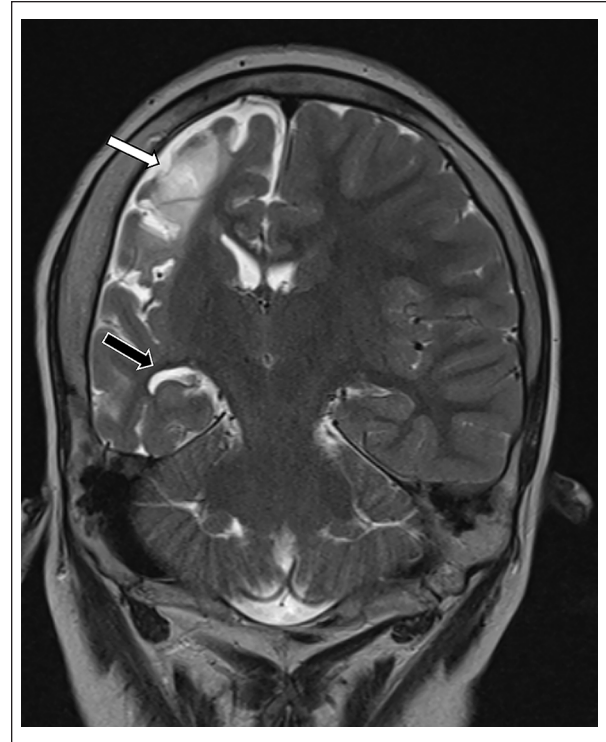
Coronal T2 of MRI sequence demonstrating an enlargement of the right sulcal spaces (White arrow) and ipsilateral choroidal fissure (Black arrow).
